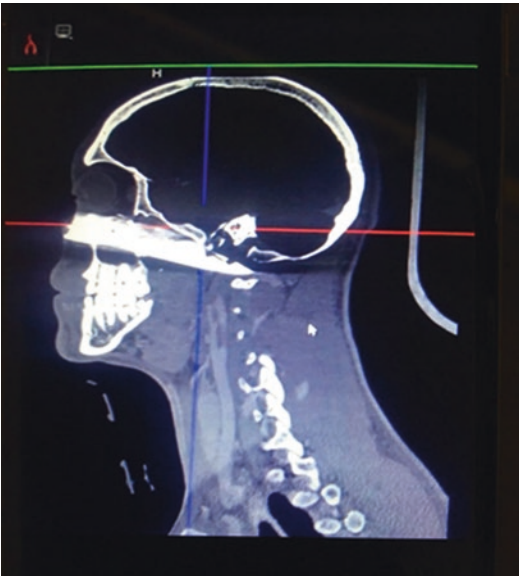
Scout sagittal CT brain showing knife blade-penetrating stab wound to neck zone 3
